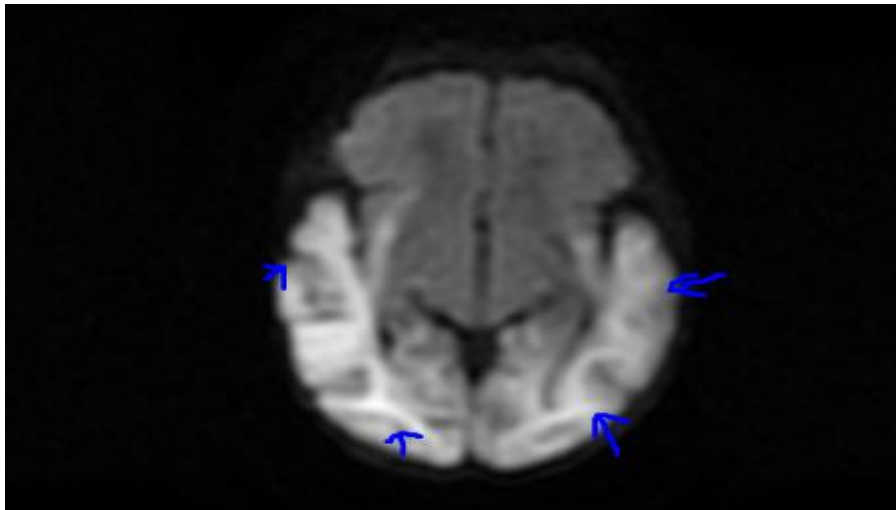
Axial Diffusion Weighted Image of Brain MRI: Bilateral temporo - parieto-occipital cortex diffusion abnormalities in Hypoglycaemic Brain Injury.
